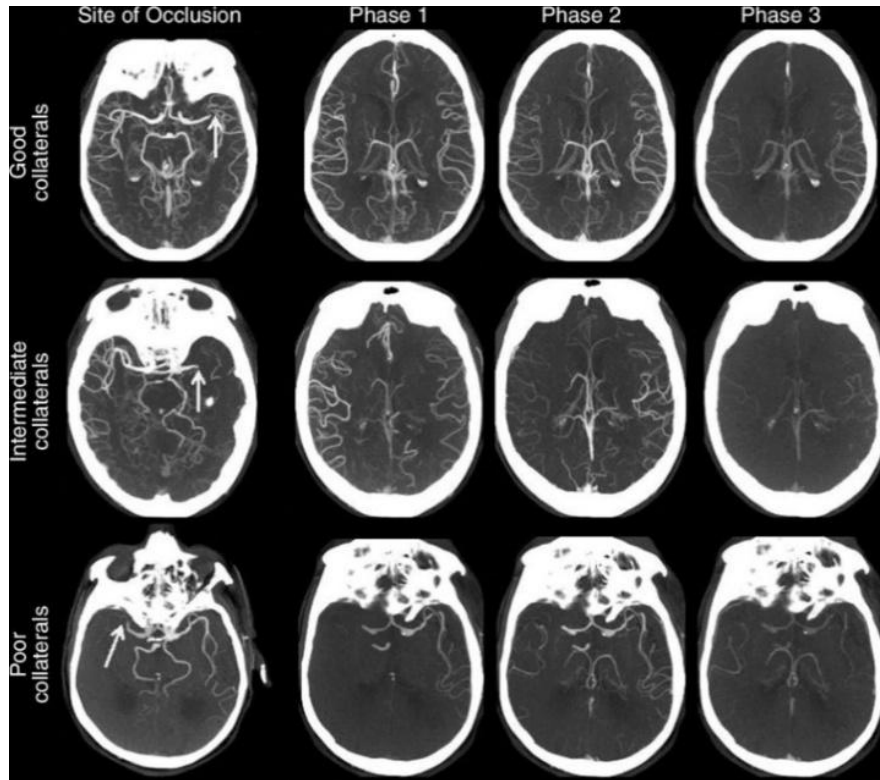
Scoring collateral circulation on multi-phase CT angiography in the axial plane. Top row: Occlusion in the left M1 middle cerebral artery with effective collaterals (filling with delay in one phase, but normal coverage); Middle row: Left M1 middle cerebral artery occlusion with moderate collaterals (filling with delay in one phase and reduced coverage); Bottom row: Left M1 middle cerebral artery occlusion with inadequate collaterals (no initial filling and minimal visible collaterals in subsequent phases) (Menon et al., 2015).
